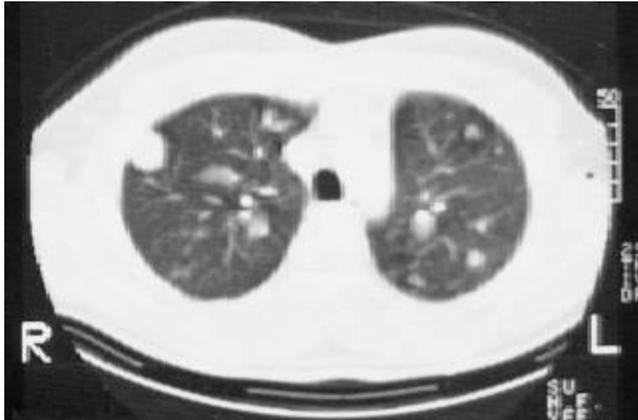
Transverse thin section CT scan obtained at the level below aortic arch shows multiple, well defined nodular lesions of varying sizes, distributed in peribroncho-vascular and sub-pleural locations in both upper lobes and one of the nodule on right side shows central low attenuation area suggestive of necrosis.
